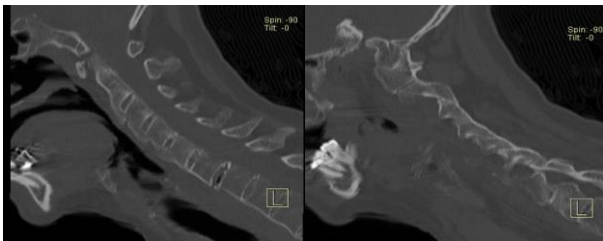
A. Cervical CT: Transdiscal C6-C7 fracture.
